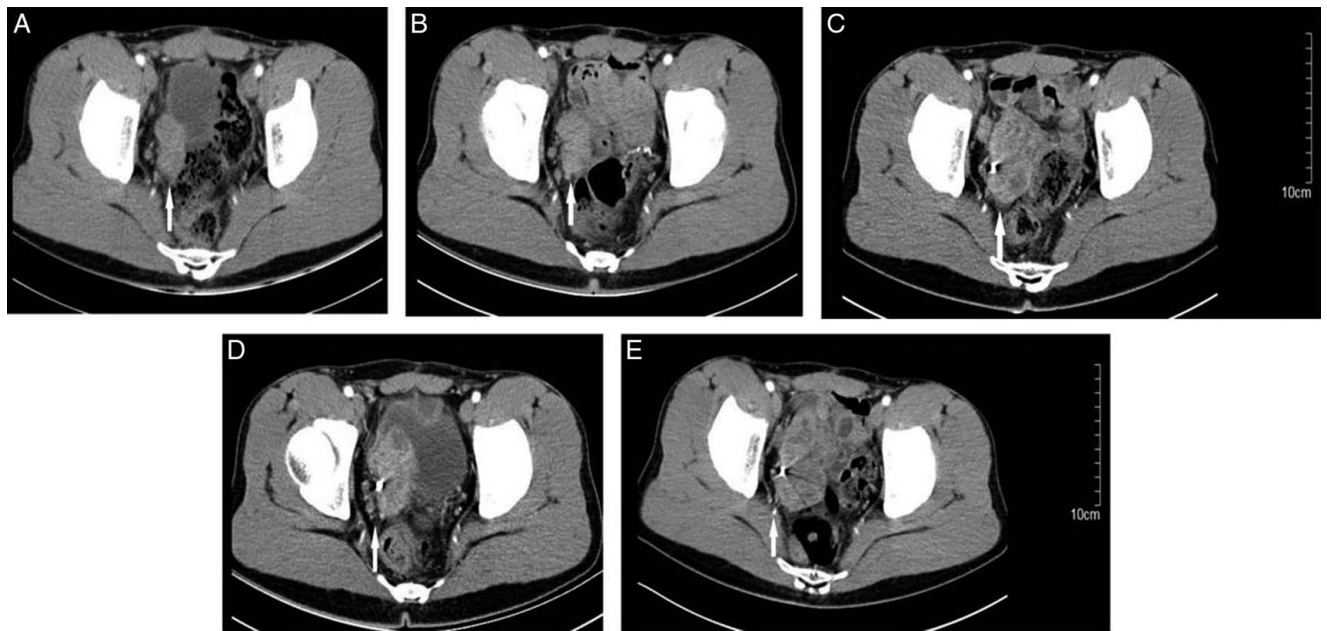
(A) Pelvic CT (2016.05.02) showed that the longest diameter (LD) of target lesion (TL) was ~4.5 cm. (B) Pelvic CT (2016.06.07) showed circa 4.6 cm of the LD and SD after apatinib treatment. (C) Pelvic CT (2016.09.27) showed the LD increased to 6.4 cm and PD after apatinib treatment. (D) Pelvic CT (2016.10.31) showed the LD was stable at 6.4 cm and SD after treatment with the combination of apatinib with temozolomide. (E) Pelvic CT (2017.01.02) showed that the LD of the TL was 9.1 cm and PD after treatment with the combination of apatinib with temozolomide.
